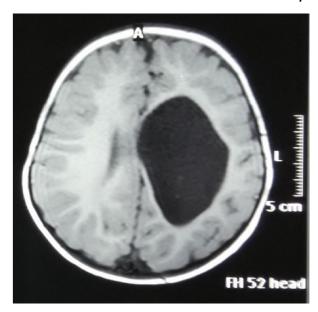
MRI brain of the same patient showing asymmetrical dilatation of left lateral ventricle with mild atrophy of left cerebral hemisphere, Sulci in left frontoparietal region are prominent
